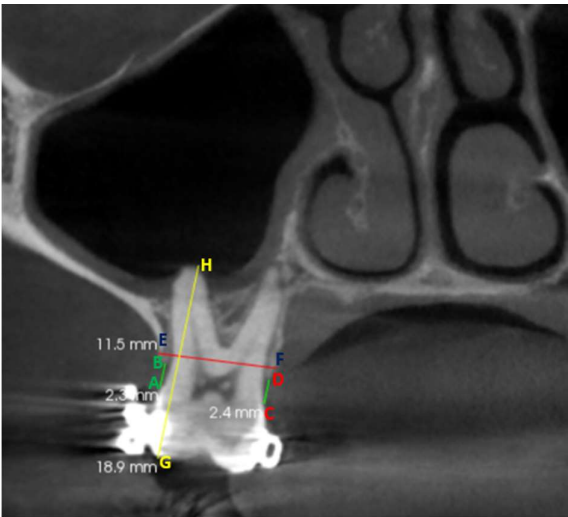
(b)-Post-retraction CBCT measurement of alveolar bone height,width and vertical changes
